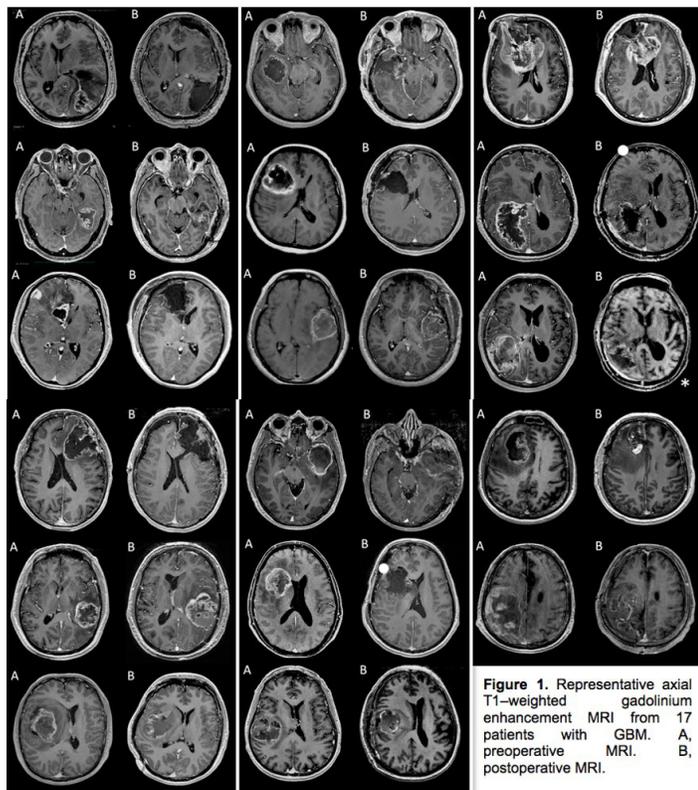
Representative axial T1-weighted gadolinium enhancement MRI from 17 patients with GBM. A, preoperative MRI. B, postoperative MRI.
